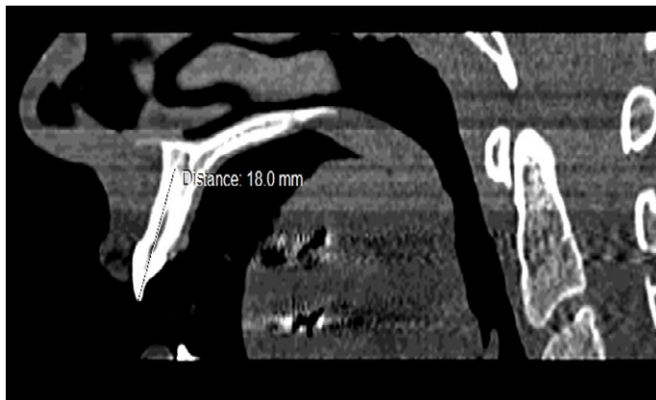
The total tooth length: sagittal CT view.
